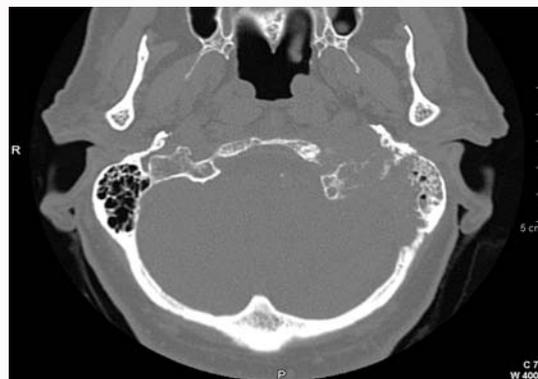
Axial high-resolution CT scan of the temporal bones shows an extended osteolytic erosion of the left temporal bone, including the mastoid and petrous apex.
